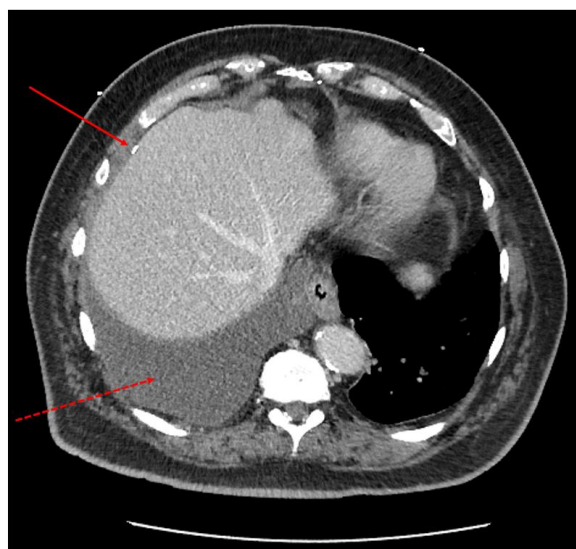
Axial CT scan image showing a right pleural effusion [dotted line arrow] and a fluid collection above the liver centered around a retained dropped cholecystectomy clip [solid line arrow]
